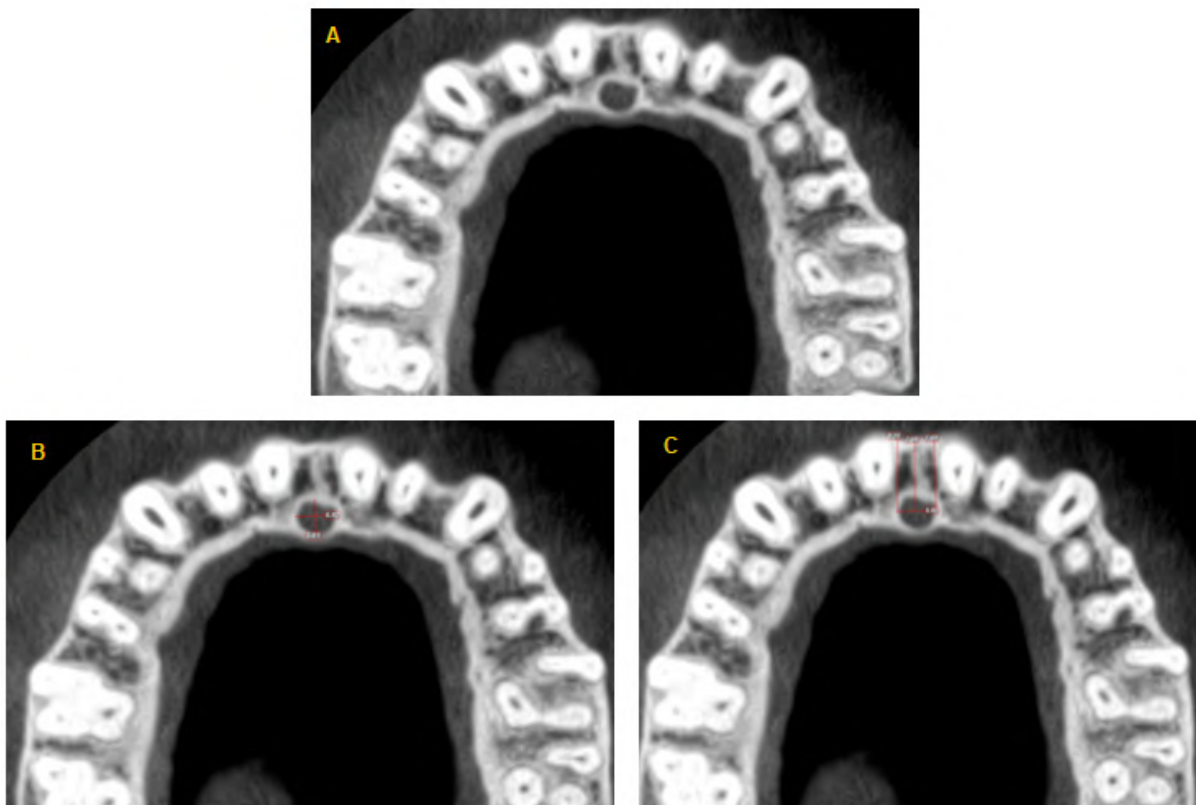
CBCT image of the Incisive foramen (A = Incisive foramen, B = Longitudinal and Transverse Diameters of IF, C = Labial Bone Thickness in relation to IF).
